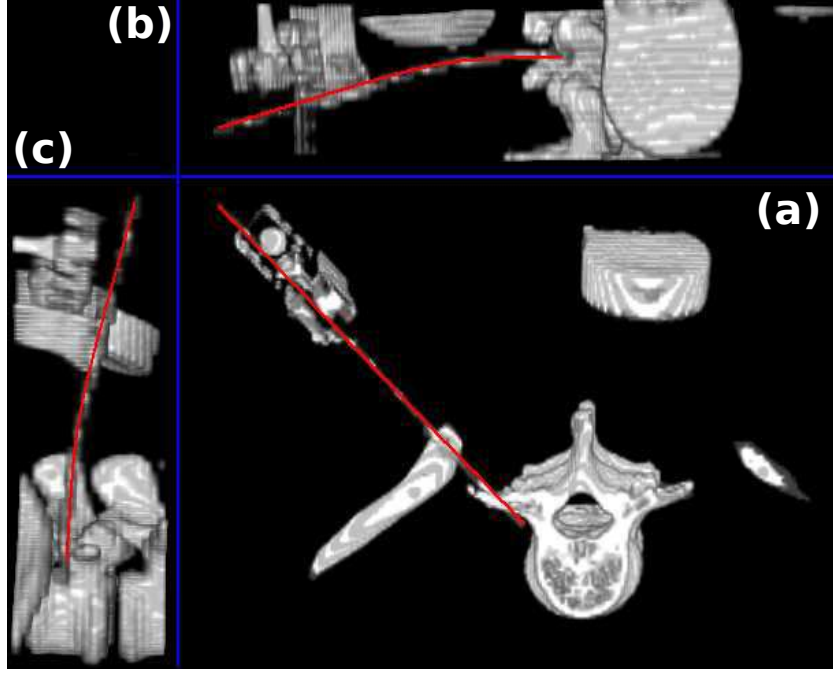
3D reconstruction of a needle used in a medical intervention from CT images. *a)* Overall view of needle deflection, *b)* Sagittal section: visualization of the bending of the needle, *c)* Coronal section: visualization of the bending of the needle.
